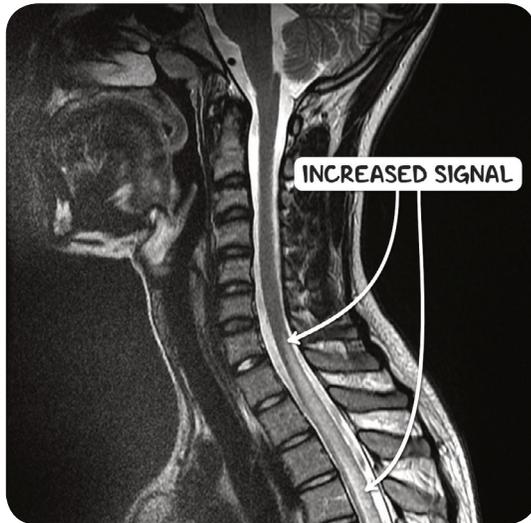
An MRI scan of the spine in the sagittal plane demonstrating increased T2 signal uptake in the spinal cord, typical of transverse myelitis, extending from C7 downwards and ending at T12 (not shown).
